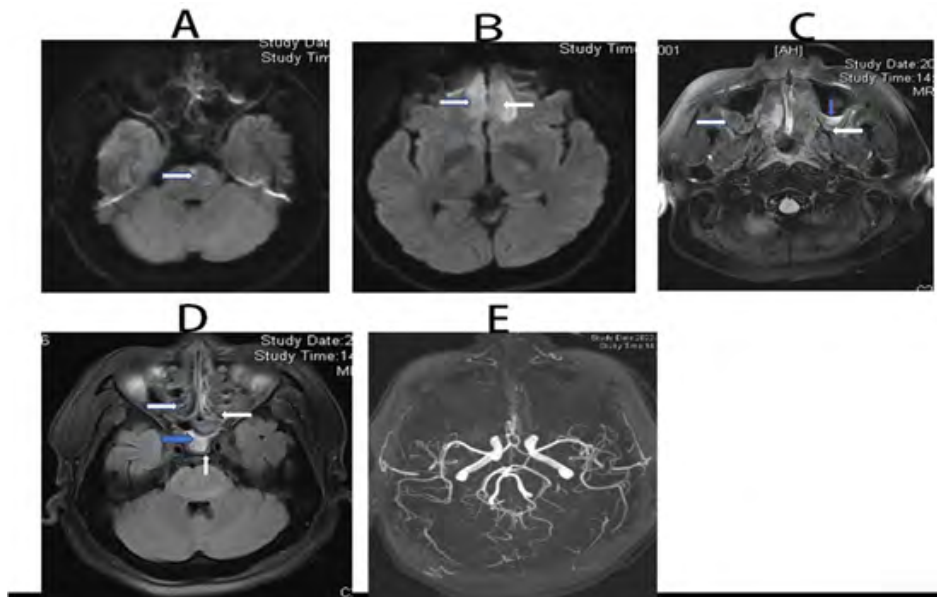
MRI and MRA image of brain
